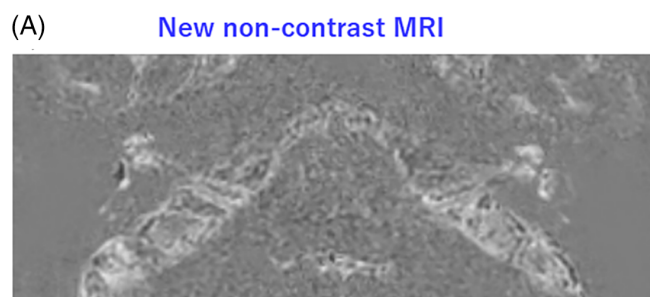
New non-contrast MRI of Patient 7. Patient 7 was a 52-year-old woman with Stage 3 right-sided Ménière's disease. (A) Image of the inner ear at the cerebellopontine angle; (B) magnified images of the inner ears. Lesions with decreased signal intensity in Patient 7 are apparent in the new non-contrast MRI; they are consistent with images considered to represent endolymphatic hydrops in the vestibule and cochlea.
